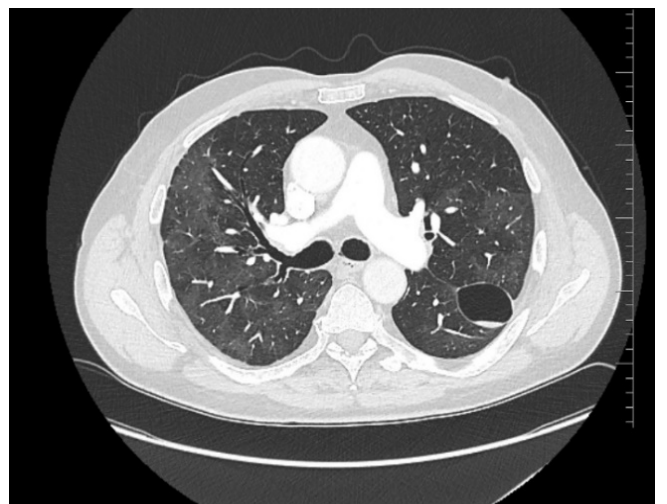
An axial CT scan demonstrating a lung cyst in the left lung.
